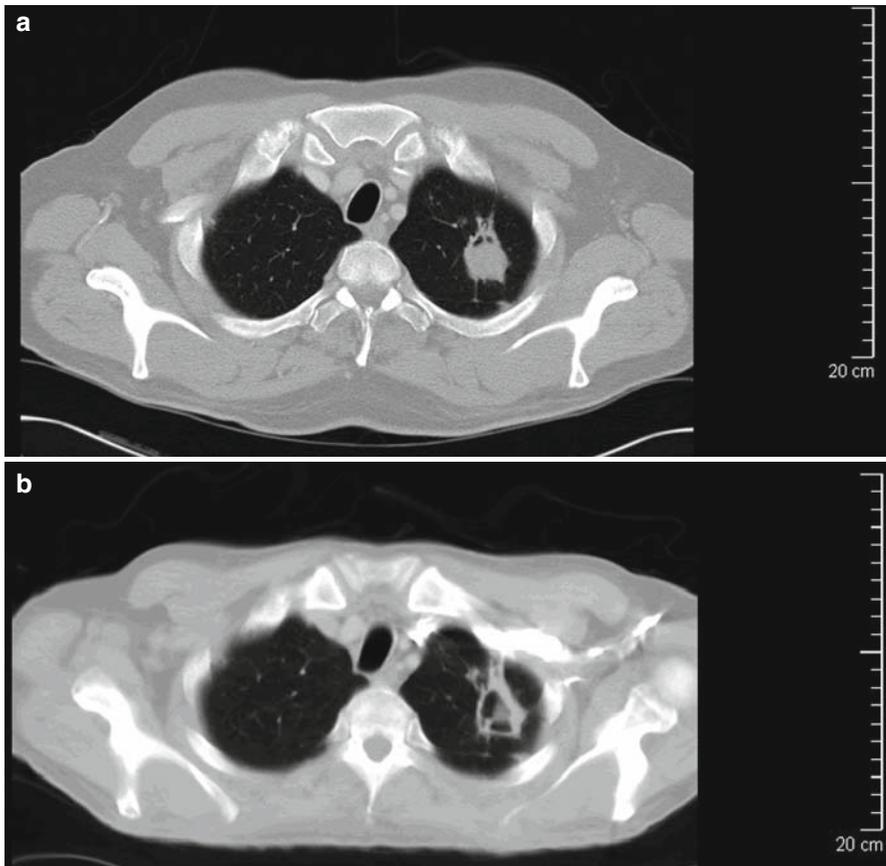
(a) Chest computed tomography (CT) scan of a patient with acute myelogenous leukaemia showing a *left upper* lobe mass with air crescent cavitation consistent with invasive pulmonary aspergillosis. Few months after antifungal therapy, the chest CT showed a residual fungal ball (b)
